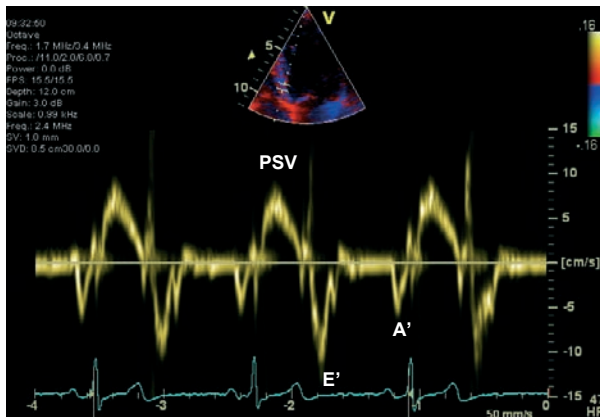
Pulsed-wave tissue Doppler imaging in the apical 4-chamber view in a normal individual. The pulsed-wave sample is placed on-line in the region of interest (basal part of the inter-ventricular septum) and the myocardial velocity curve is derived. (PSV = peak systolic velocity, E' and A' represent diastolic parameters).
